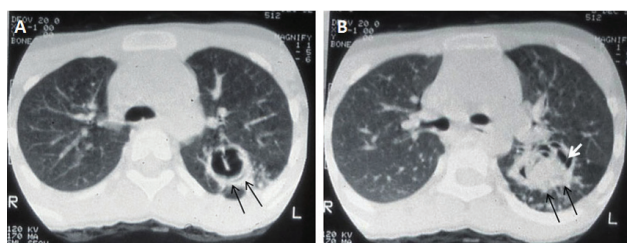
Chest computed tomography (CT) scans showing the mass (black arrows in A and B) with air bubbles (white arrow in B).
